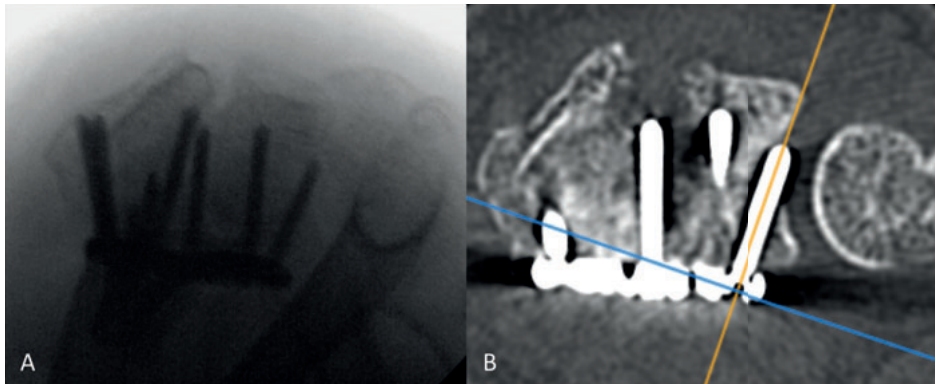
One remaining screw that was not changed during the index procedure but -in hindsight- should have been identified on the DTV images intra-operatively (A) as it proved to violate the DRUJ on the post-op CT reference standard (B).
